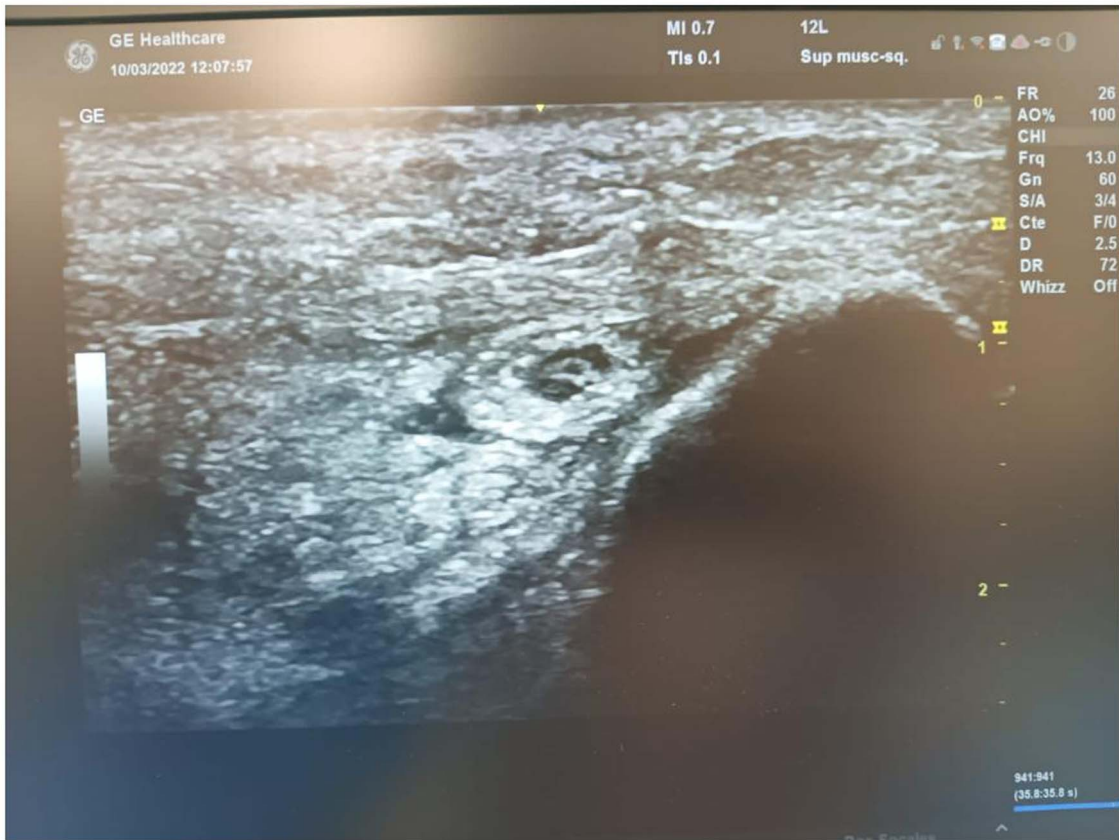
A transverse sonogram showing the compression site of ulnar nerve at medial elbow.
